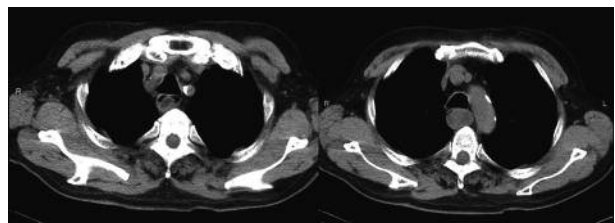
Chest CT showing an intraesophageal mass
